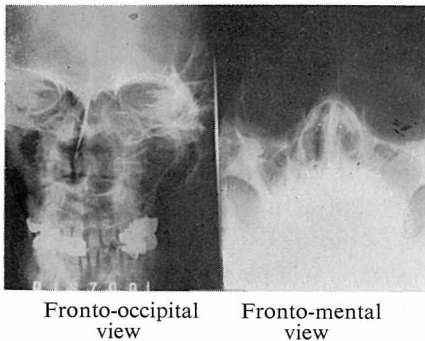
Simple X-Ray examination of the paranasal sinuses.
